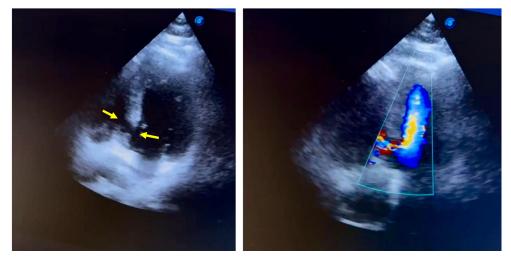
Rupture of interventricular basal septum (arrows) in a case with acute myocardial infarction (2D and color Doppler, apical 4-chambers view) Other complications
